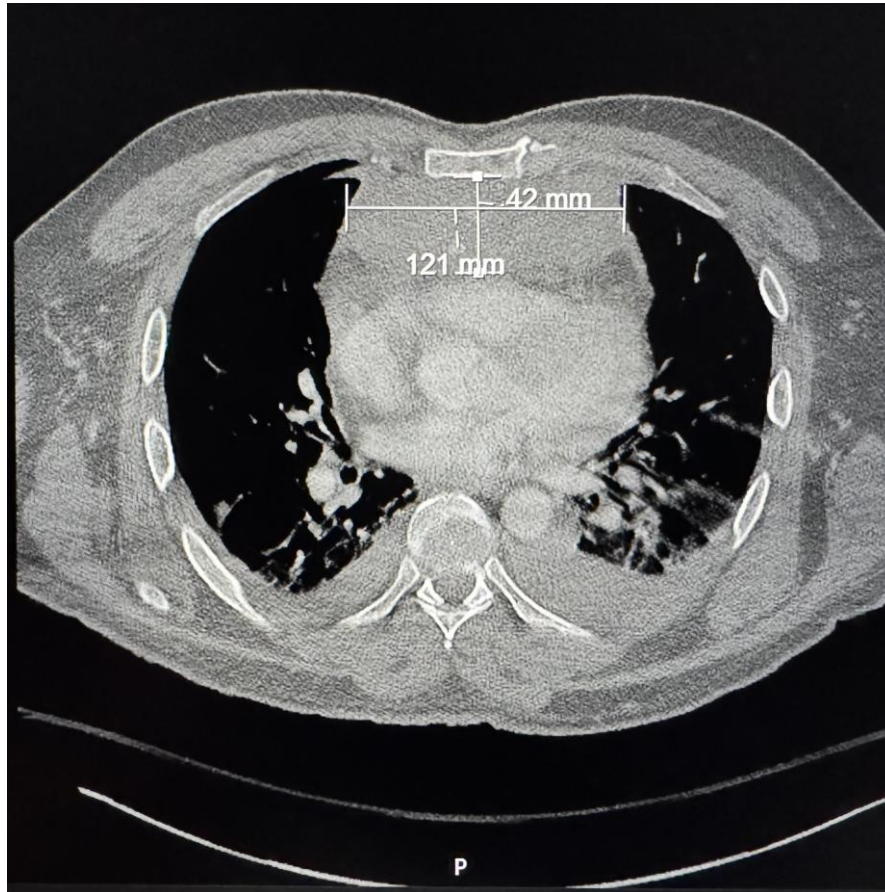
Early CT scan showing sternal fracture with retrosternal haematoma.
